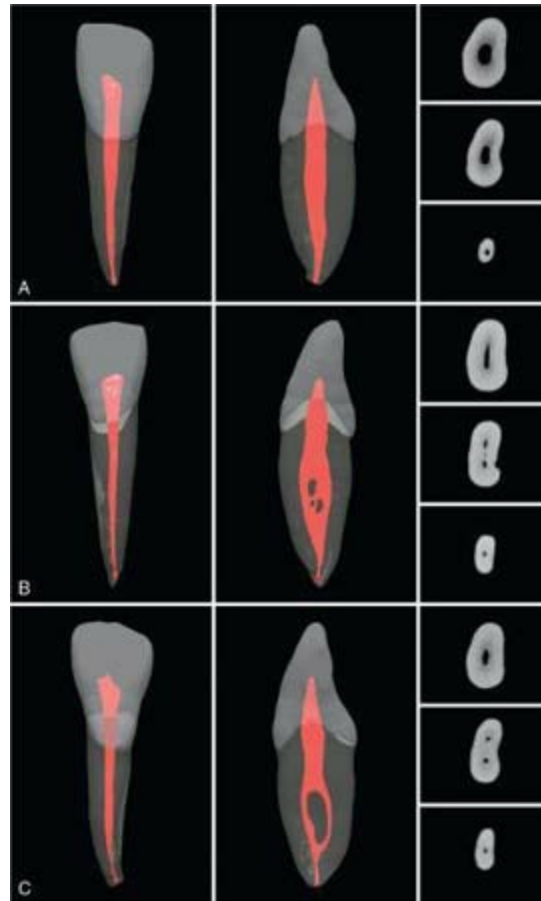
μ CT scans of mandibular lateral incisors. A, Common anatomic presentation. B, Lateral incisor with broad, thin buccolingual anatomy. C, Lateral incisor in which the canal splits into two but returns to form one canal apically. All teeth are shown from both a buccal (vestibular) and a proximal perspective, along with the cross-sectional anatomy at the coronal, middle, and apical levels. (See Video 7.13 online at the Expert Consult site for rotational views of these teeth.)
